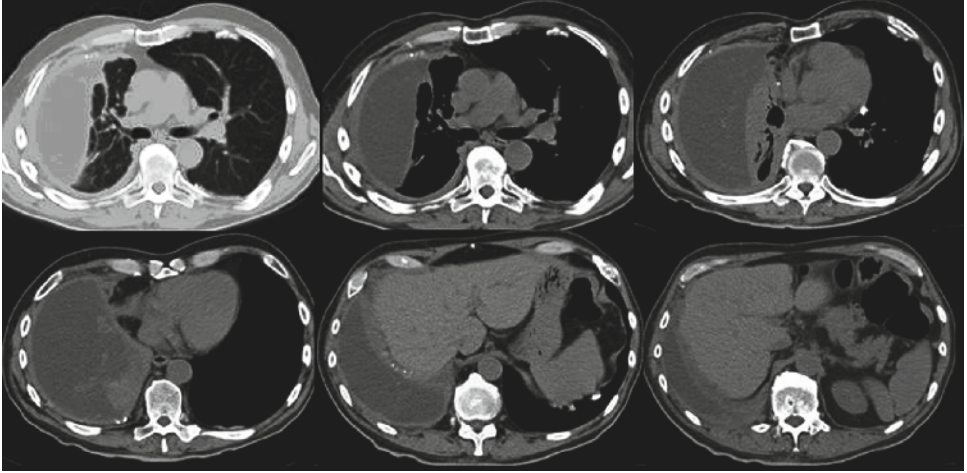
Serial axial CT images showing pleural effusion, thickening, and masses
